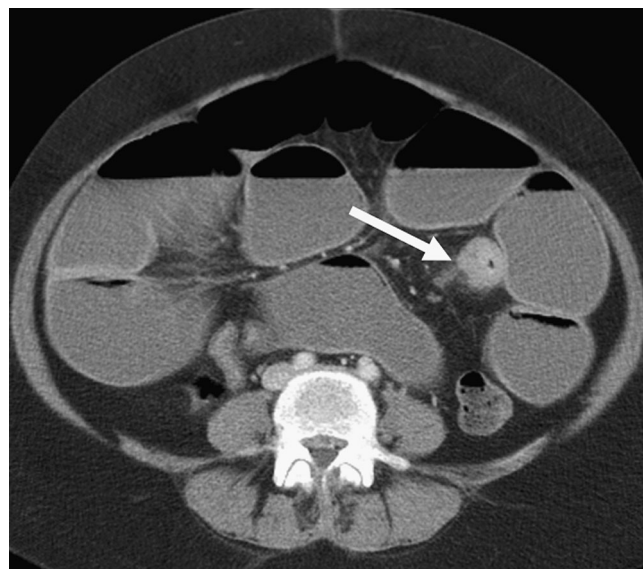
A 40-year-old female with established Crohn's disease presents with a high-grade small bowel obstruction. CT shows marked small bowel dilatation with an annular, slightly asymmetric stricture (arrow) in the proximal ileum. The wall thickening is relatively homogeneous and there are small adjacent mesenteric nodes.
